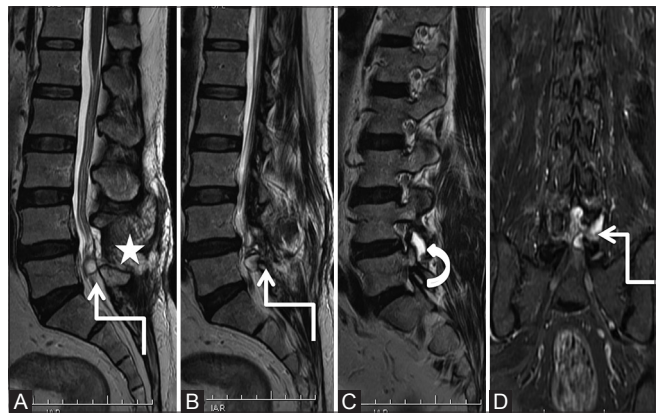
(A-D): Degenerative: Synovial cyst: Postoperative scan at 3 months with patient having left lower limb radiculopathy: Sagittal T2-weighted (A-C) and coronal short T1 inversion recovery (D) images show a well-defined lobulated hyperintense cystic lesion (elbow arrow) in the posterior epidural space at L4-5 level, which communicates with fluid in the left L4-5 facet joint (star). Note postoperative changes in the parasagittal region (star)
